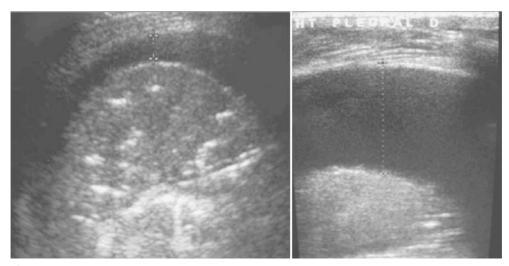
Ultrasound evaluation showing an echogenic focus that has resulted in a pleural effusion
